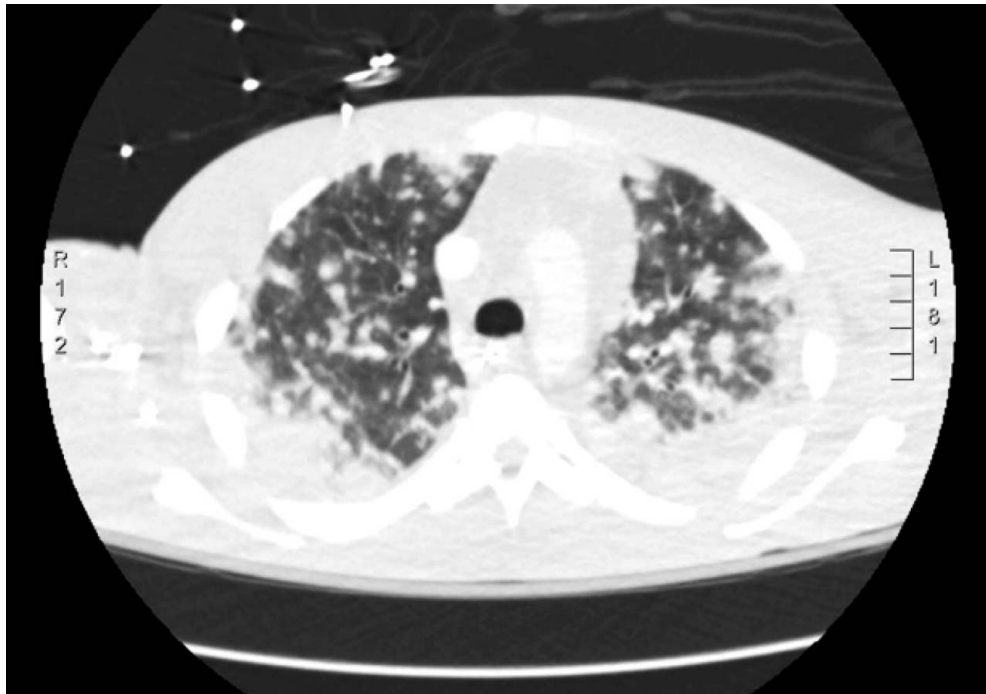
As shown by computed tomography, the patient presented with hemoptysis, likely secondary to the large tumor burden in his lungs.
